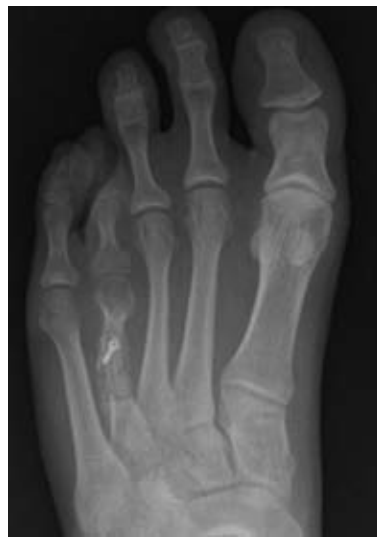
Post-operative AP radiograph at 6 weeks of the left foot showing the lengthening scarf osteotomy, incorporation of the bone blocks and fixation with an Omnitech[®] screw of the 4th metatarsal. The 4th metatarsal head is 2 mm longer than the 5th metatarsal head.
